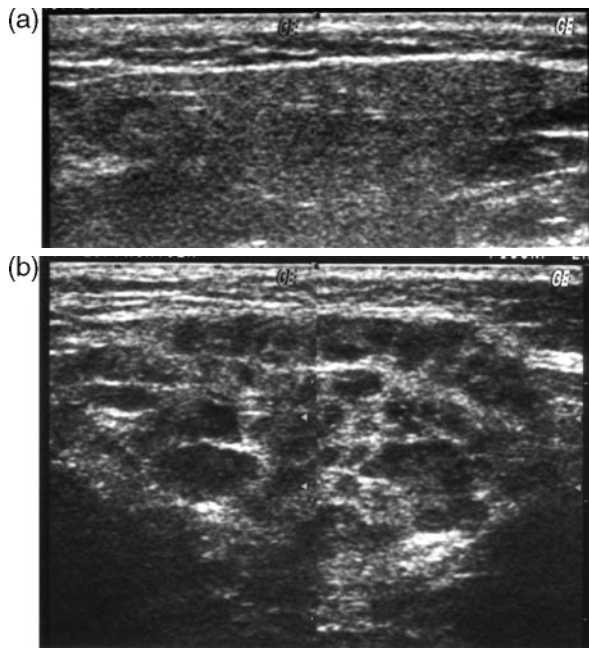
Ultrasonographic images of parotid glands with (a) normal parenchyma and (b) gross parenchymal inhomogeneity (grade 3).
